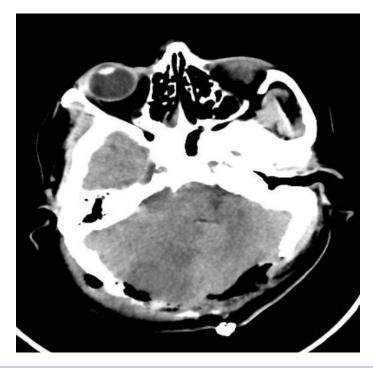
CT brain without contrast post decompressive craniotomy.
